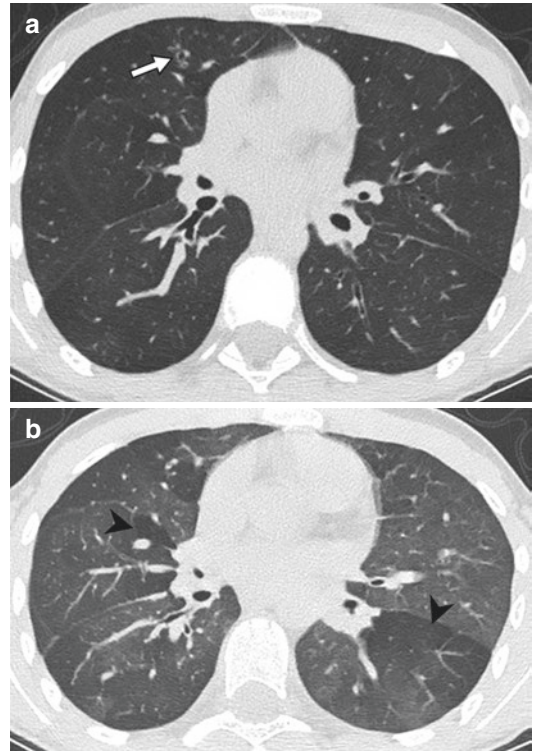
Bronchiolitis obliterans syndrome in an 18-year-old woman with acute lymphoblastic leukemia. (a) Inspiratory CT shows some dilatation of subsegmental airways in the right upper lobe (arrow). A tiny reduction in lung parenchymal density is also noted. (b) Expiratory CT performed at the same level demonstrates a significant reduction of parenchymal density representing air-trapping (arrows)
